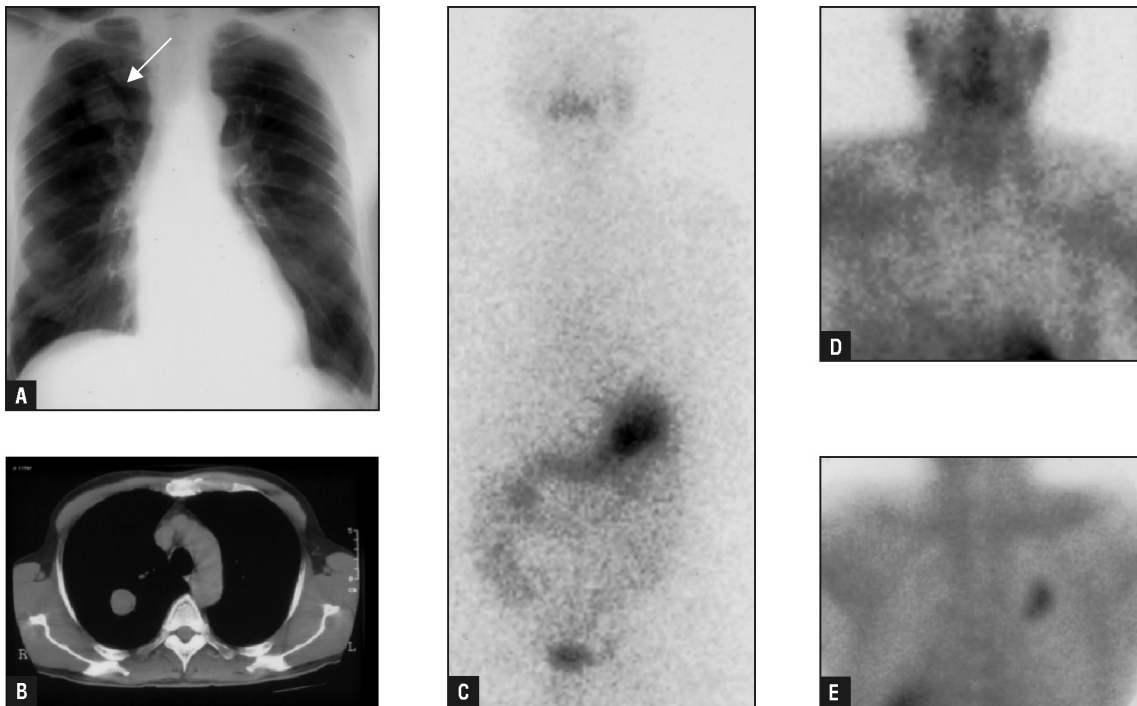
Alternative imaging in DCT. A. Chest X ray of a 52-year-old male with follicular carcinoma of the thyroid presented with rising Tg and RUL shadow (arrow); B. CT scan confirmed presence of a well-defined rounded mass in the same area thought to be a benign hamartoma; C. Whole-body ^{131}I scan was negative as was ^{201}Tl scan D; E. Posterior chest $^{99\text{m}}\text{Tc}$ -MIBI scan demonstrated uptake in the lesion that was shown on biopsy to be metastatic disease.
